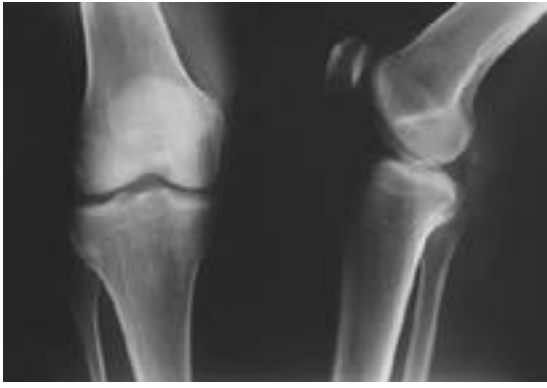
AP and lateral simple radiographs of the right knee reveal no bony lesion in the tibial and femoral bone.
